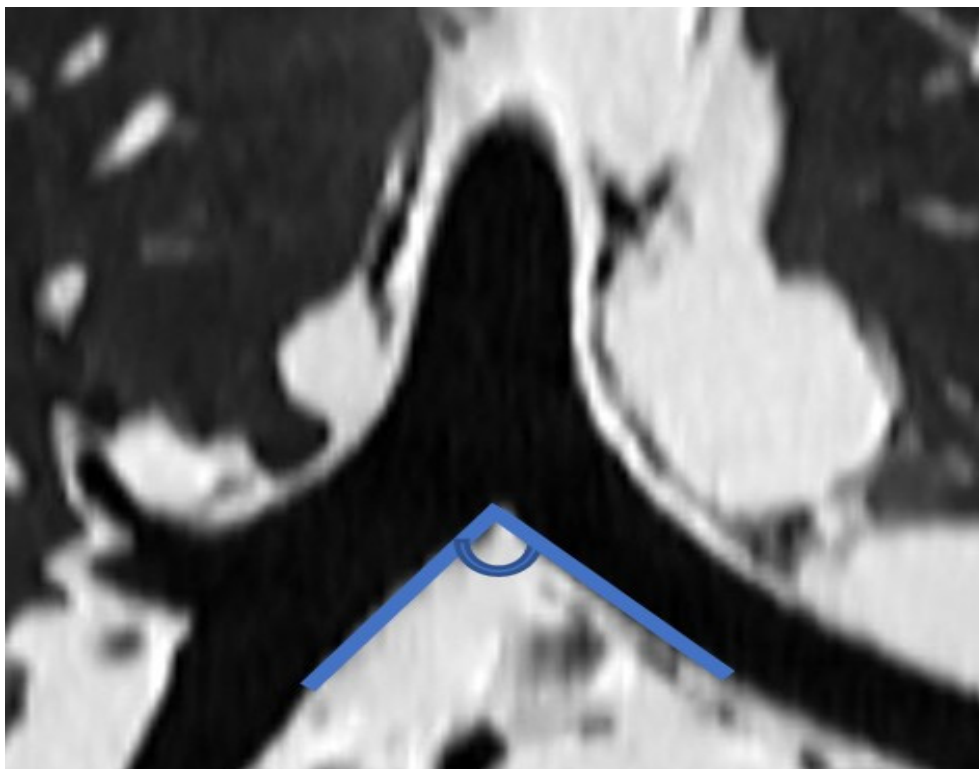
Subcarinal angle (SCA): The angle formed by the intersection of the inferior margins of the right and left main bronchi on a coronal reformatted CT image
